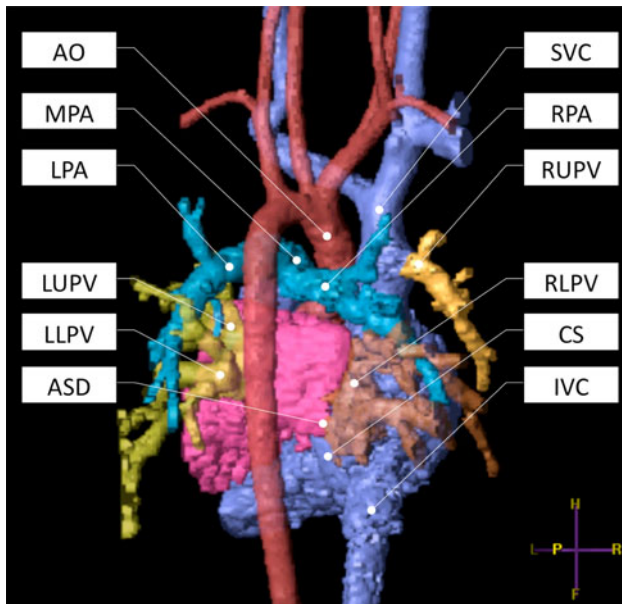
Three dimensional anatomic shaded surface contrast enhanced magnetic resonance image. A posterior view of the cardiovascular segments where the 4D flow was assessed is shown. Note the partial anomalous right upper pulmonary vein return to the superior vein cava (SVC) and the position of the atrial septal defect (ASD). AO aorta; CS coronary sinus; IVC inferior vein cava; LPA left pulmonary artery; LLPV left lower pulmonary vein; LUPV left upper pulmonary vein; MPA main pulmonary artery; RLPV right lower pulmonary vein; RPA right pulmonary artery; RUPV right upper pulmonary vein
